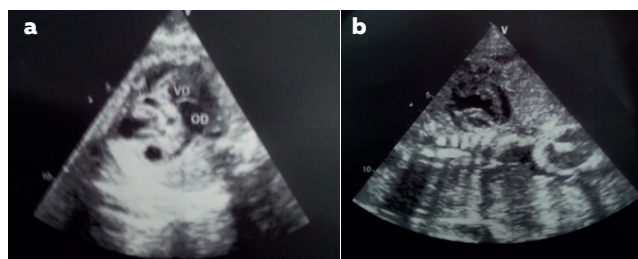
Fetal echocardiography at 26 weeks' gestation showing a mediastinal mass : axial view (a) sagittal view (b).
